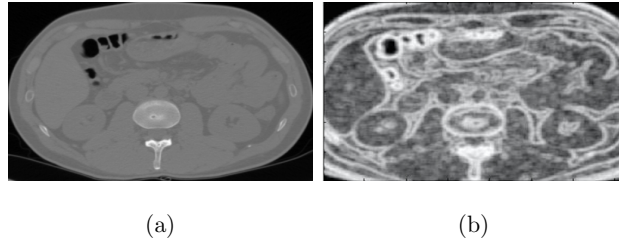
The figure shows (a) a CT slice and (b) the map constructed based on its local entropy.
